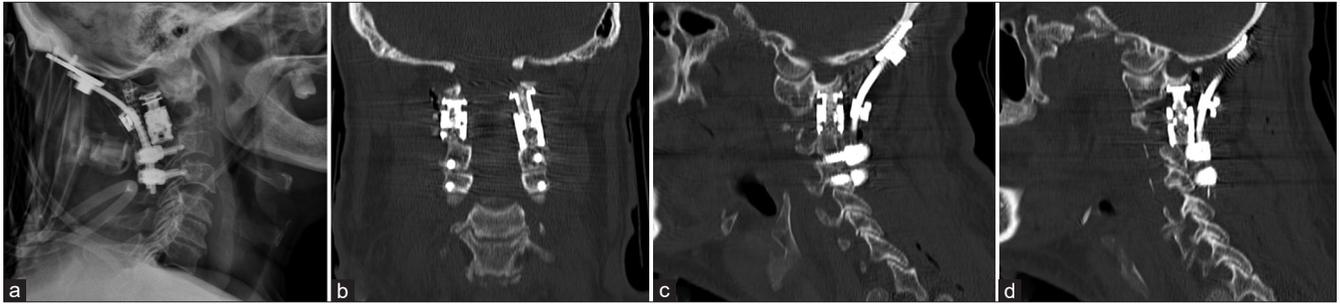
Immediate postoperative lateral craniocervical X-ray (a) and computed tomography scan (b: Coronal, c: Right parasagittal, and d: Left parasagittal).
